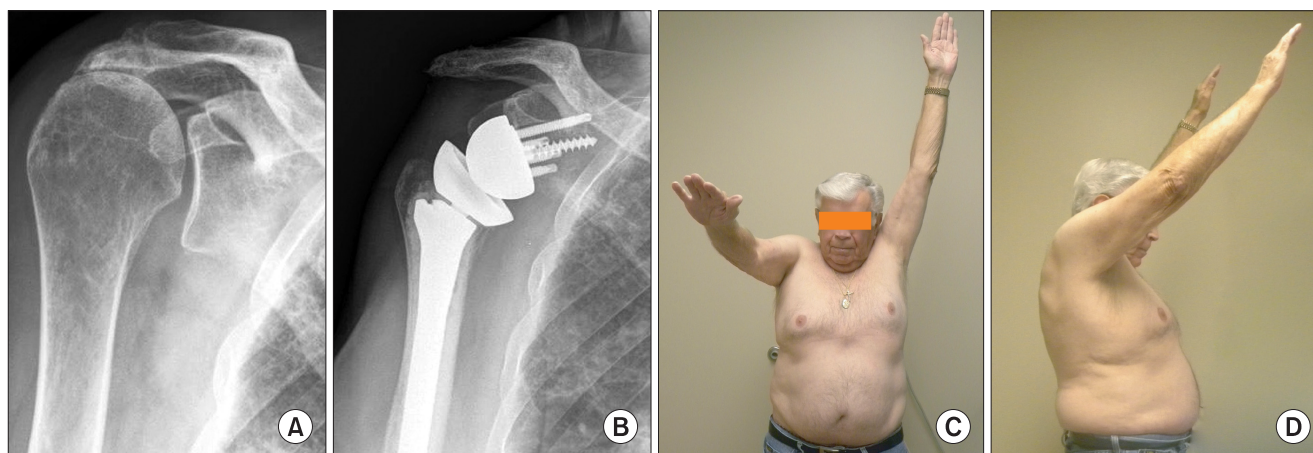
A 78-year-old male patient with massive rotator cuff tear without arthritis. (A) Preoperative conventional anteroposterior radiograph of the shoulder shows proximal migration of the humeral head without glenohumeral arthritic change. (B) Conventional anteroposterior radiograph of the shoulder at 12 months' follow-up shows satisfactory positioning of the prosthesis with no signs of loosening. (C) Preoperative clinical picture shows active arm elevation at less than 90°. (D) Postoperative clinical picture shows active arm elevation was improved at 12 months' follow-up.
